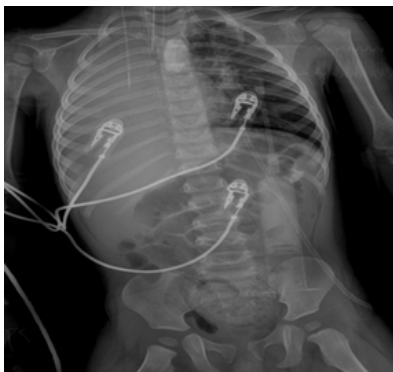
X-ray (05-24-22): Rx. chest with radio-opacity pattern in the right hemithorax with data of total right atelectasis.
